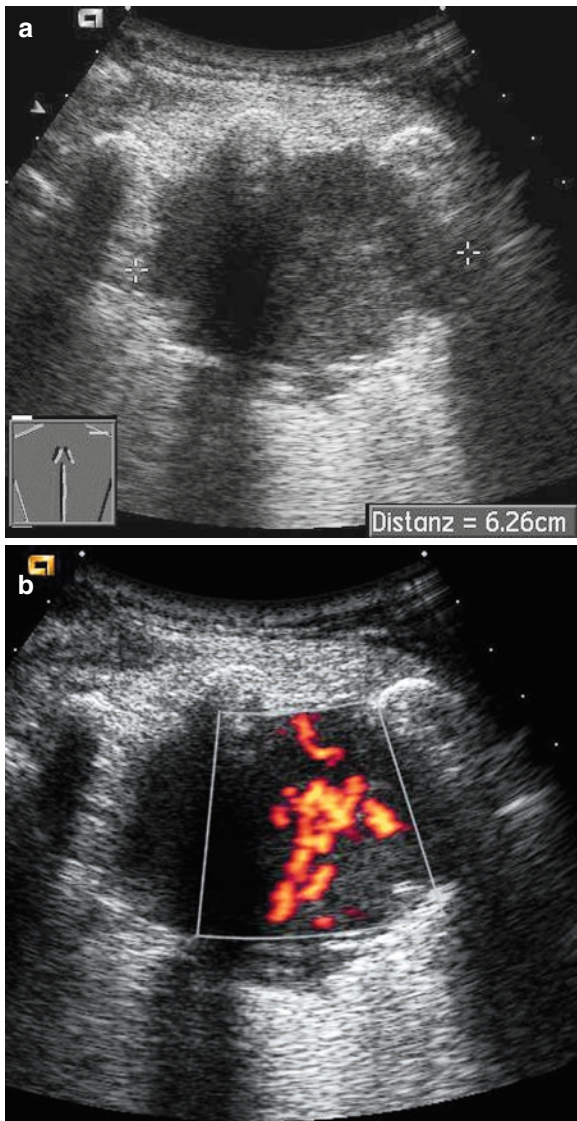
Multiple myeloma with typically strong vascularization. The diagnosis was established by sonography-guided biopsy
